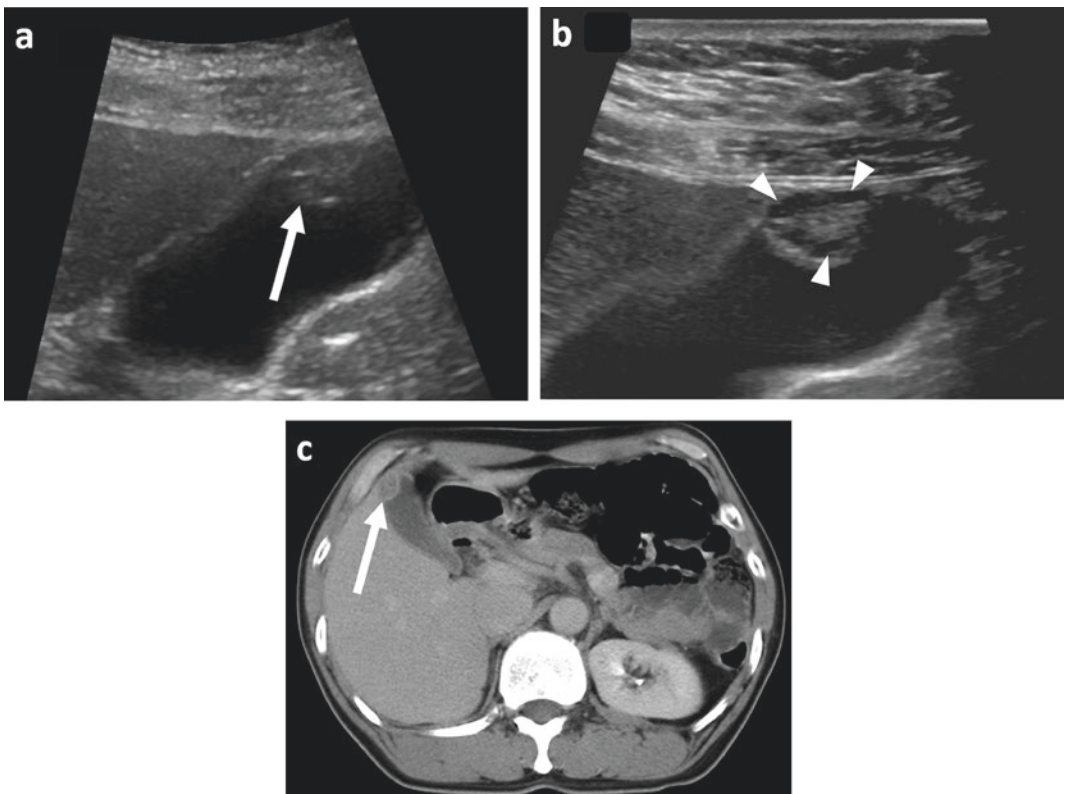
Gallbladder adenoma. a, b After position change, the polypoid lesion appeared to move on US. b On Doppler US, no blood flow signal is observed within the lesion. d On CT, the polypoid lesion is not detected within the gallbladder. The first impression of this lesion was sludge or stone, but it was confirmed as adenoma after cholecystectomy
